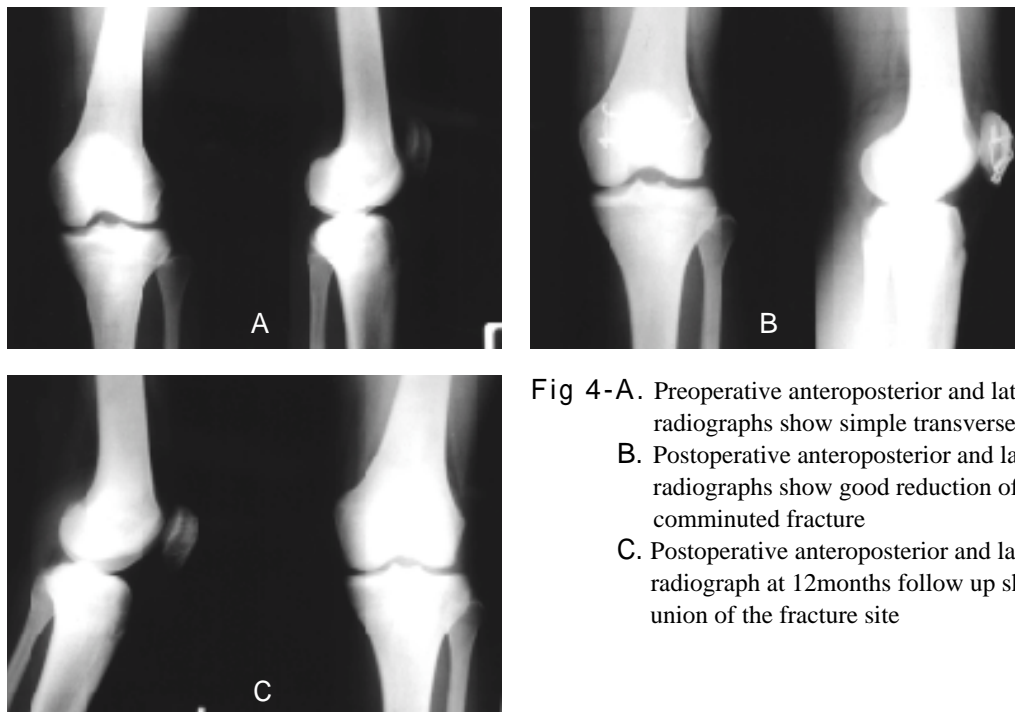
Preoperative anteroposterior and lateral radiographs show simple transverse fracture
